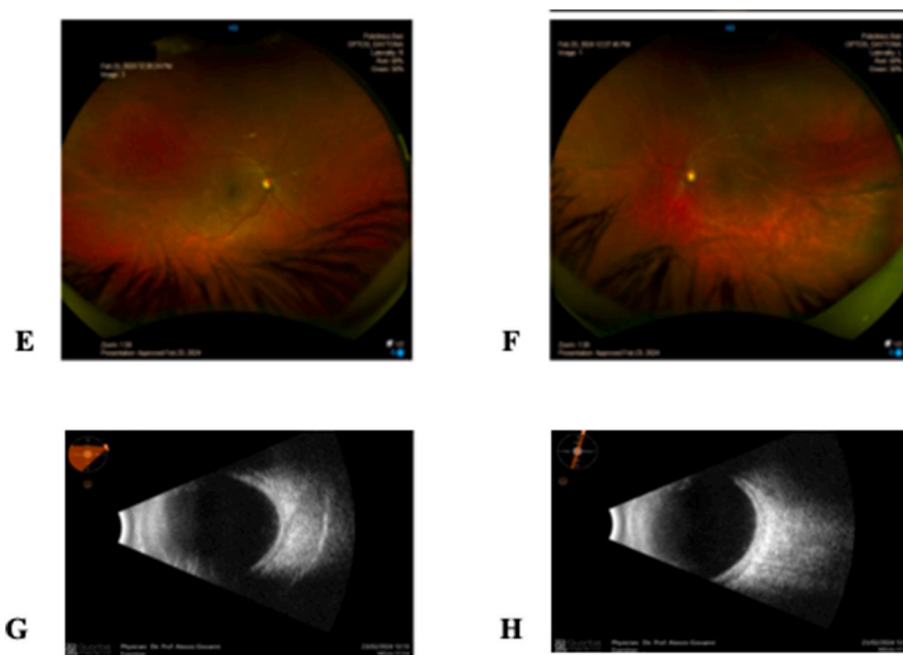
The figure displays the ocular findings after one month of controlled blood pressure therapy: some choroidal folds, complete resolution of macular edema, and total reabsorption of retinal hemorrhages were shown in the follow-up color fundus photos (E-F). The B-scan ultrasonography revealed a total resolution of choroidal detachments, with a mild choroidal thickening in both eyes, especially in the left eye (G-H).
